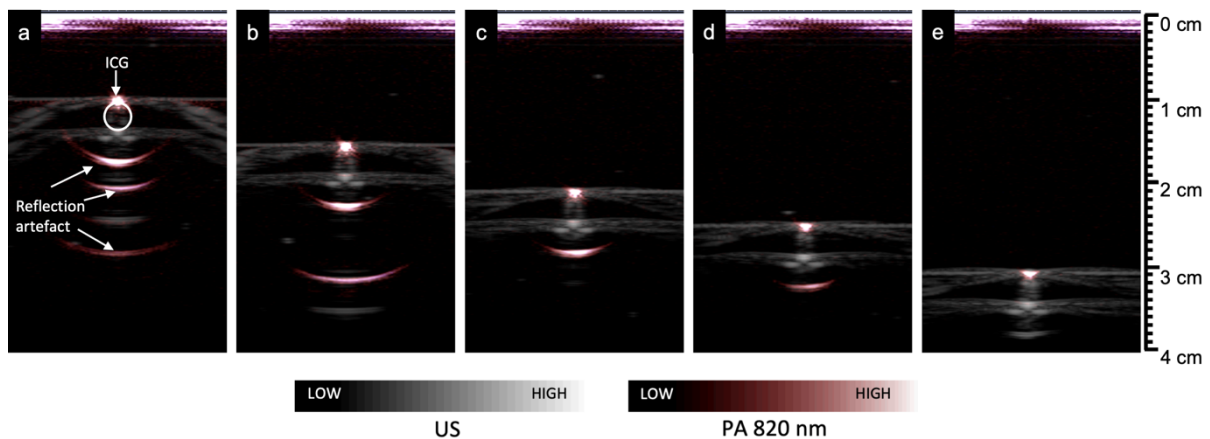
Combined photoacoustic (PA) and ultrasonic (US) images of ICG (320  $\mu\text{mol/L}$ ) at 10 mm (a), 15 mm (b), 20 mm (c), 25 mm (d) and 30 mm (e) distance from the ultrasound probe surface (PA dynamic range: 25 dB and gain: 60 dB for all images).
